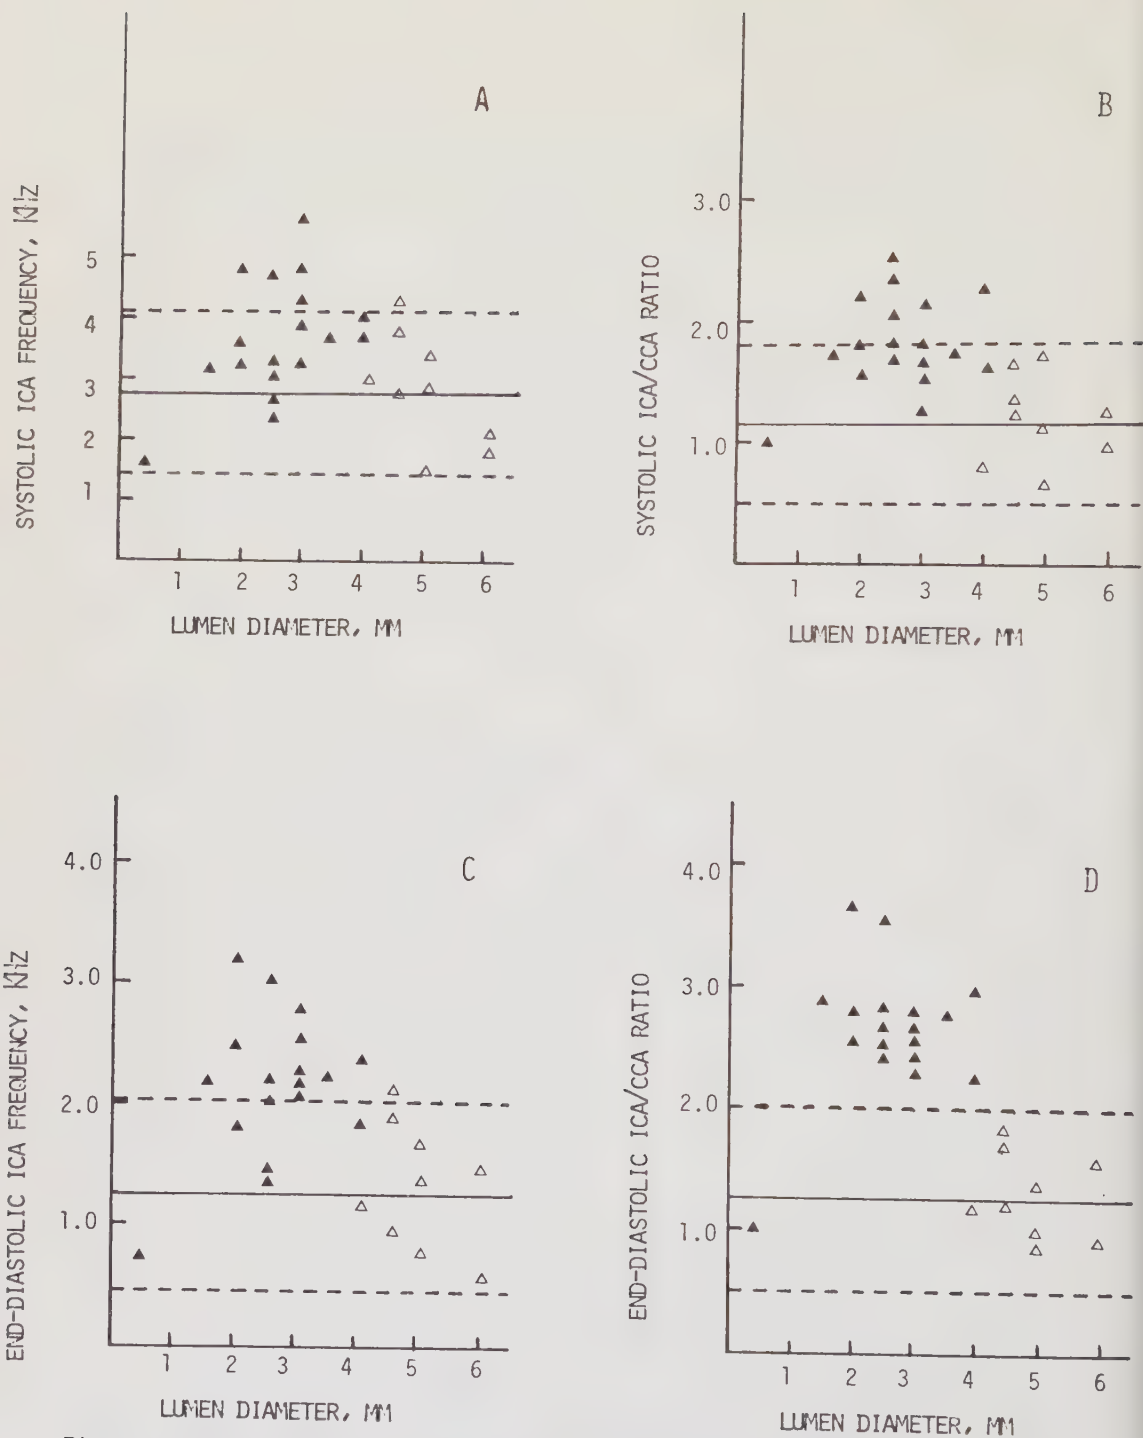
Lumen diameter (determined angiographically) related to four quantitative Doppler variables: a) systolic ICA frequency, b) systolic ICA/CCA frequency ratio, c) end-diastolic ICA frequency, d) end-diastolic ICA/CCA frequency ratio. Mean values (solid lines) and 95 % confidence interval (broken lines) in normal vessels are indicated for each variable.
